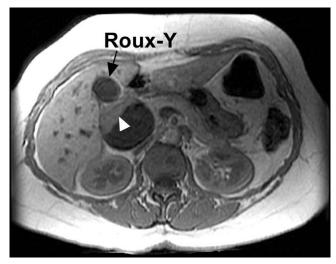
Magnetic resonance image of upper abdomen, axial image. Choledochal cyst with tumor (arrowhead) and Roux-en-Y limb of original anastomosis are demonstrated.
